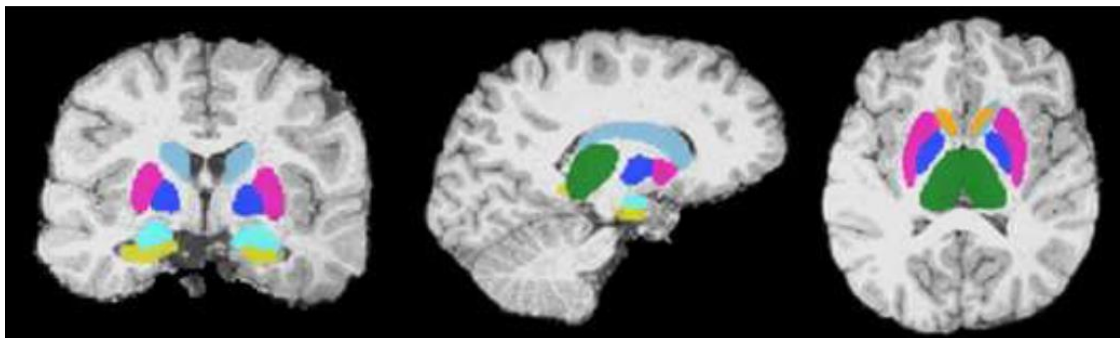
shows an example of FIRST output of subcortical structures overlaid on a T1-weighted scan. Coronal, sagittal and axial views are shown (left to right respectively). The following subcortical structures were segmented: caudate (blue-grey), nucleus accumbens (orange), putamen (pink), globus pallidus (dark blue), thalamus (green), amygdala (bright light blue) and hippocampus (yellow).
